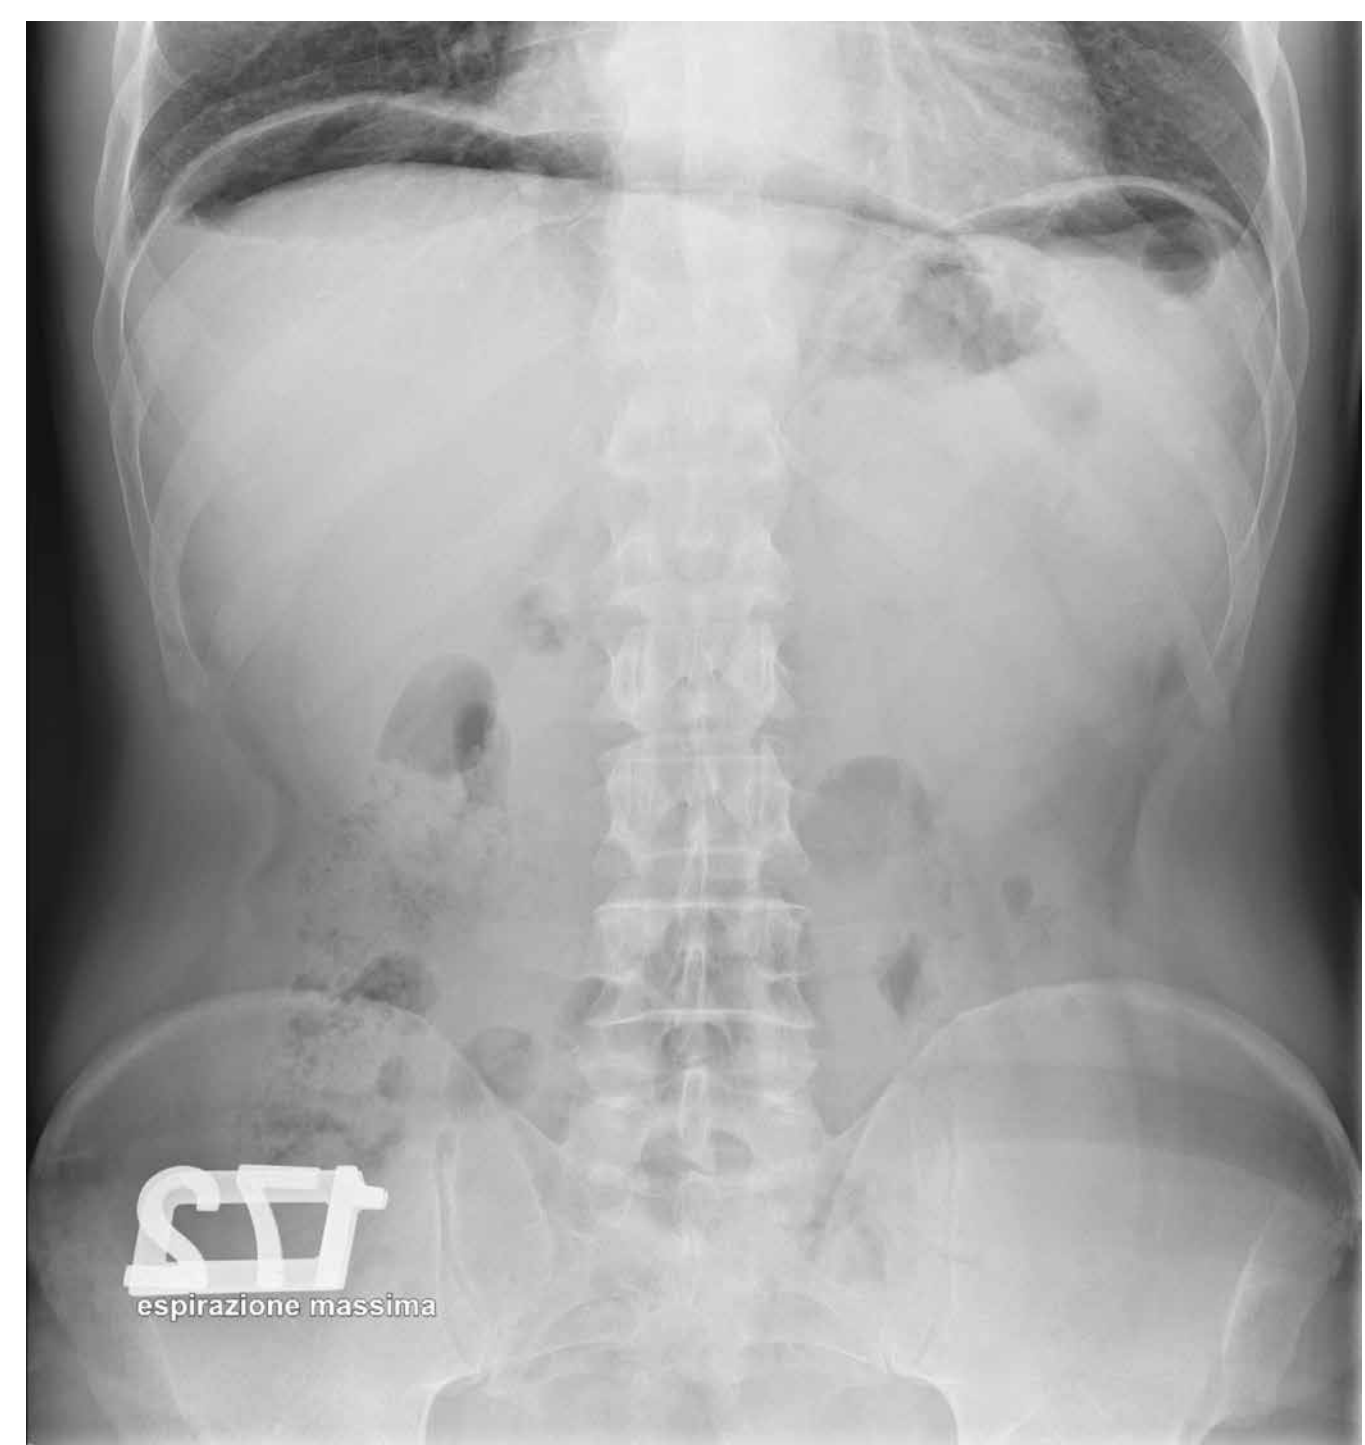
Plain film obtained at maximum expiration, demonstrates increased amount of free under the diaphragm, in keeping with hollow viscus perforation. In surgery, perforated duodenal ulcer was demonstrated.
